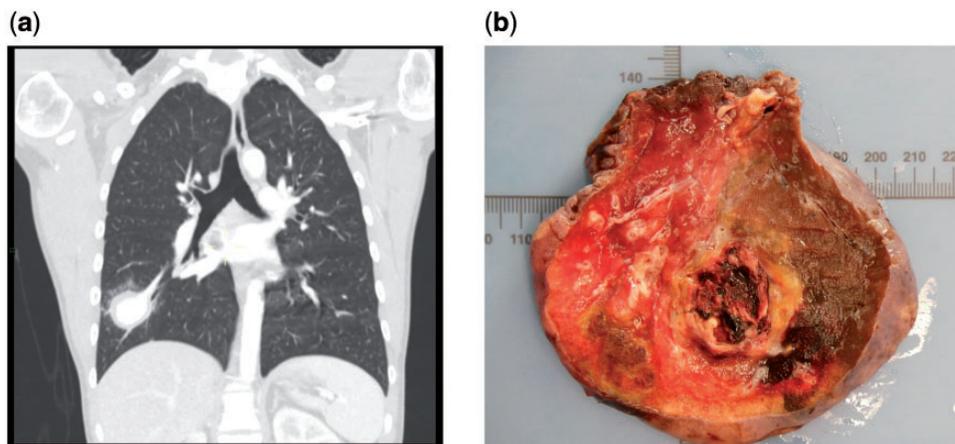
(a) CT chest demonstrating 35 mm right lateral segmental PAA. (b) Resected pulmonary artery aneurysm and adjacent pulmonary infarction.
